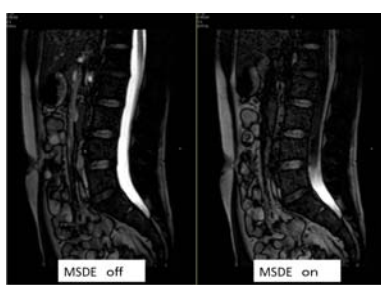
One frame of cine MR imaging in the lumbar spine. With iMSDE, the anterior part of the CSF space shows signal decrease, which may be useful to analyze flow mechanism of CSF.
